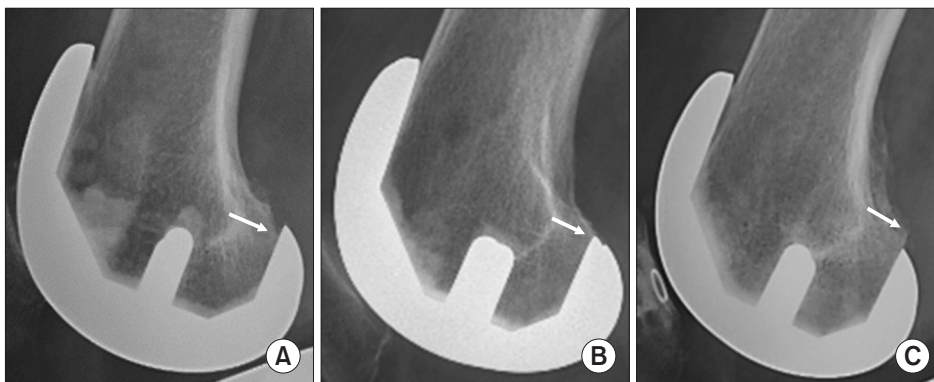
Measurement of posterior component fitting. (A) Overhang was defined when the posterior component protruded > 3 mm. Good fit (B) and underhang (C) on 30° flexion lateral radiographs. The white arrows indicate the extent to which the femoral component covers the posterior condyle of the femur.
